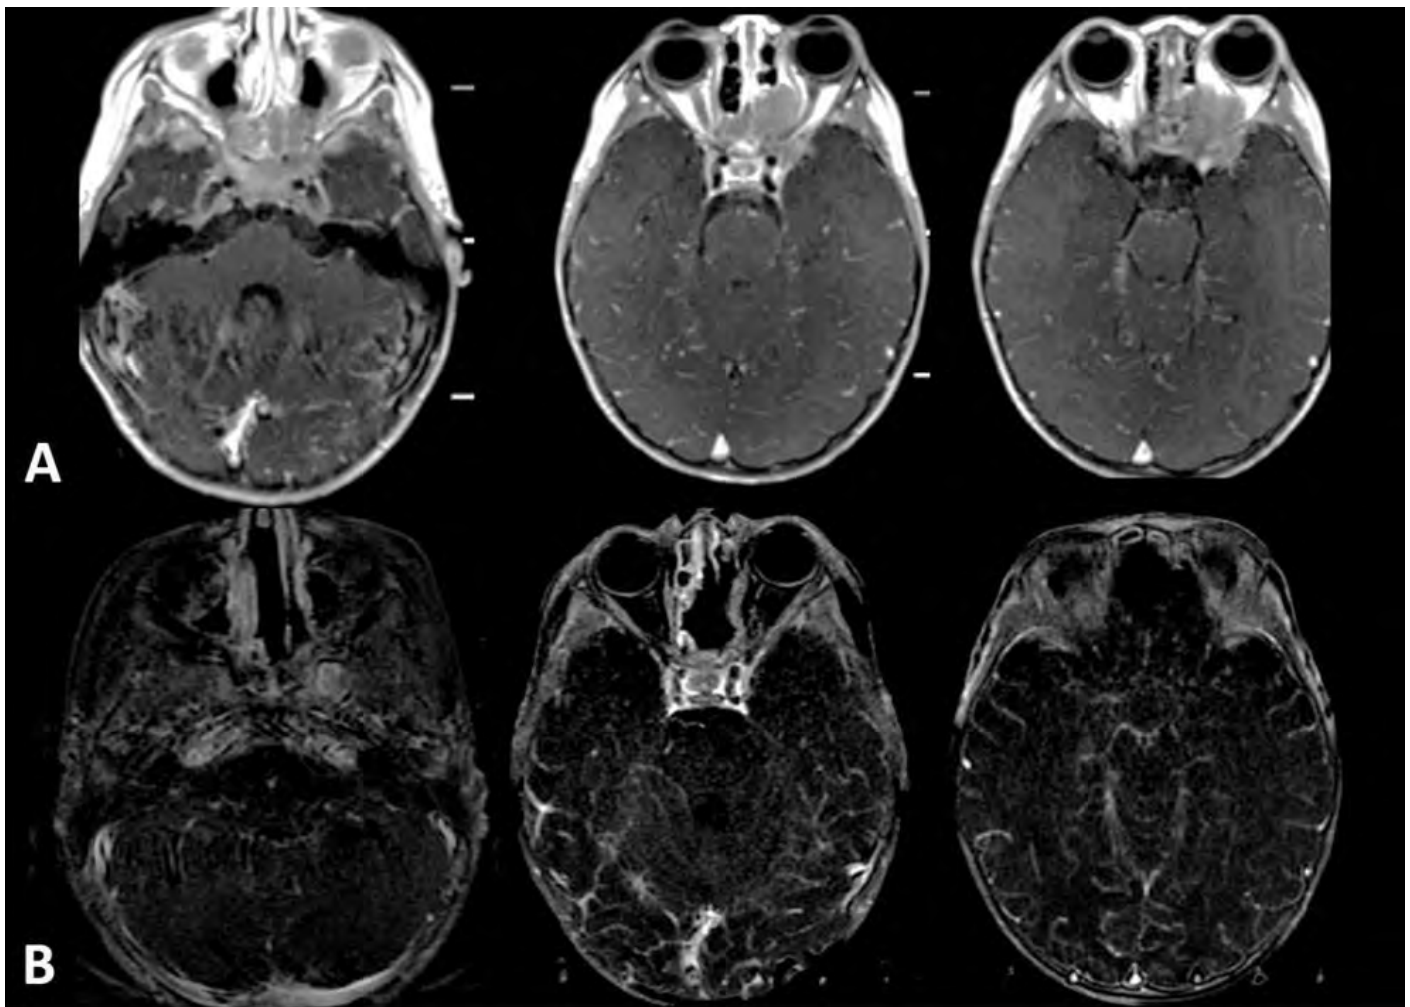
Comparative images. A. preoperative T1WI post gadolinium MRI.; B. postoperative T1WI post gadolinium with subtraction MRI demonstrating complete surgical resection of the residual tumor. An adequate decompression of the orbit as well as the optic canal can be seen.
